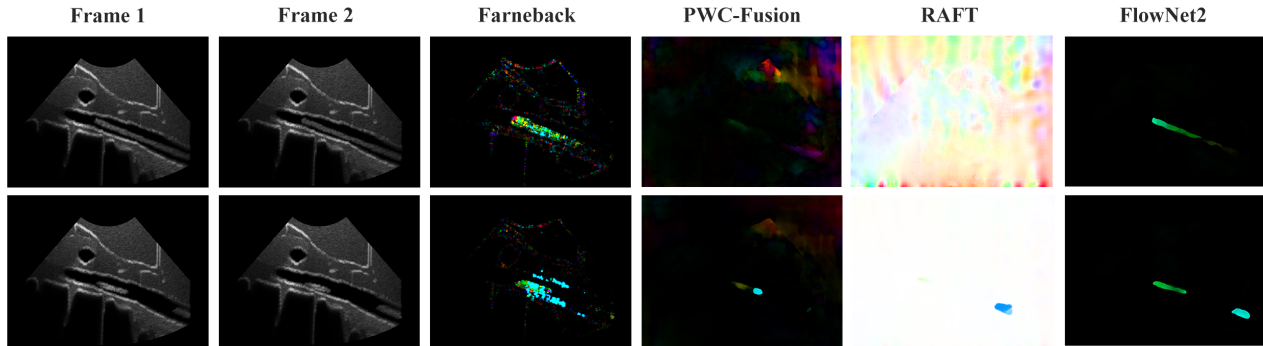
Different optical flow generation methods and respective generated optical flow on ultrasound sequence.
